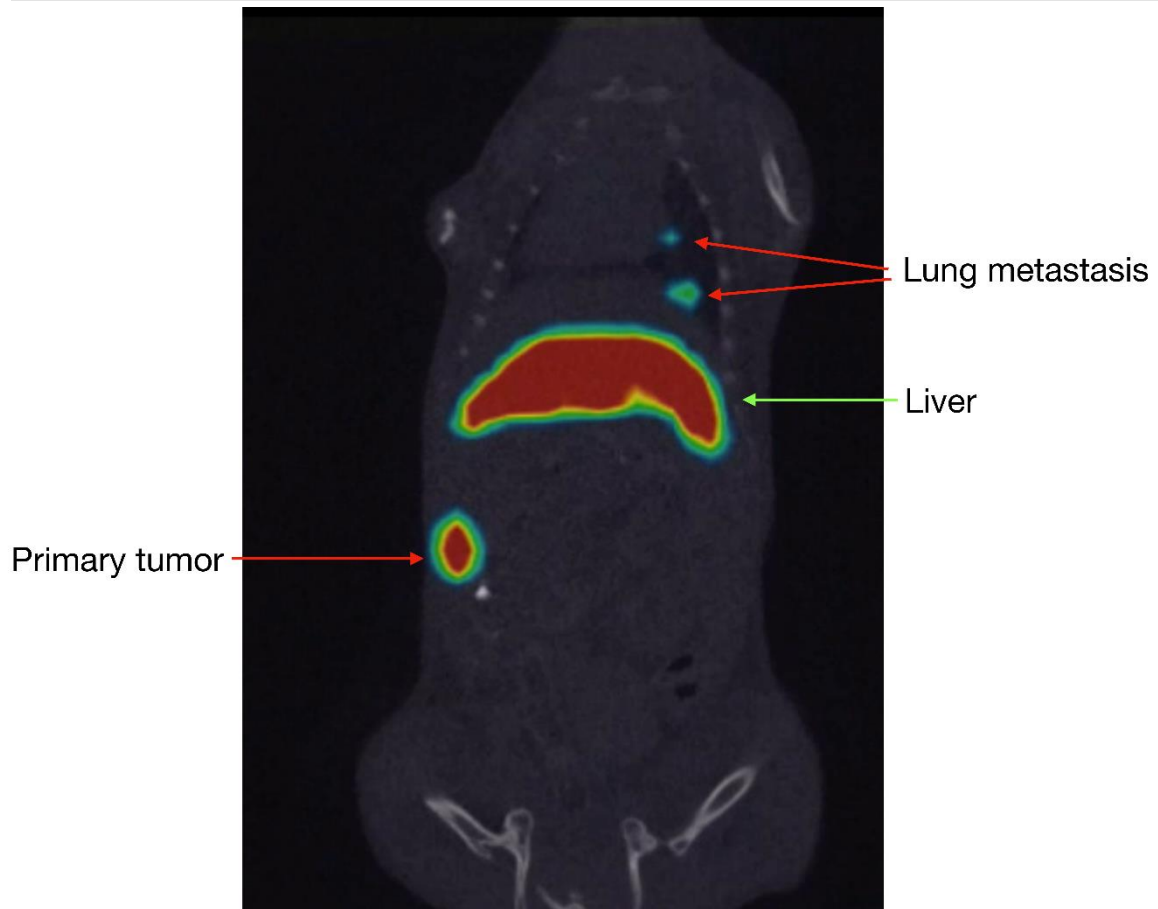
^{99m}Tc -Ixolaris microSPECT/CT showing liver uptake (normal biodistribution) and the primary and tumor and lung metastasis one hour after intravenous administration of the radiopharmaceutical.
